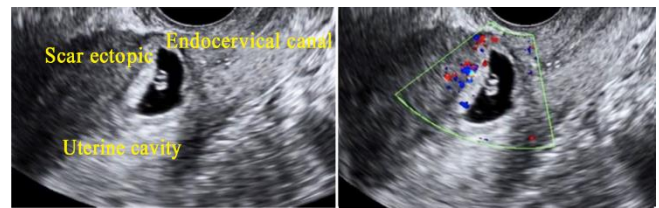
Ultrasound showing empty uterine cavity and endocervical canal. Ectopic pregnancy seen at the level of previous caesarean scar. Doppler study shows increased vascularity
